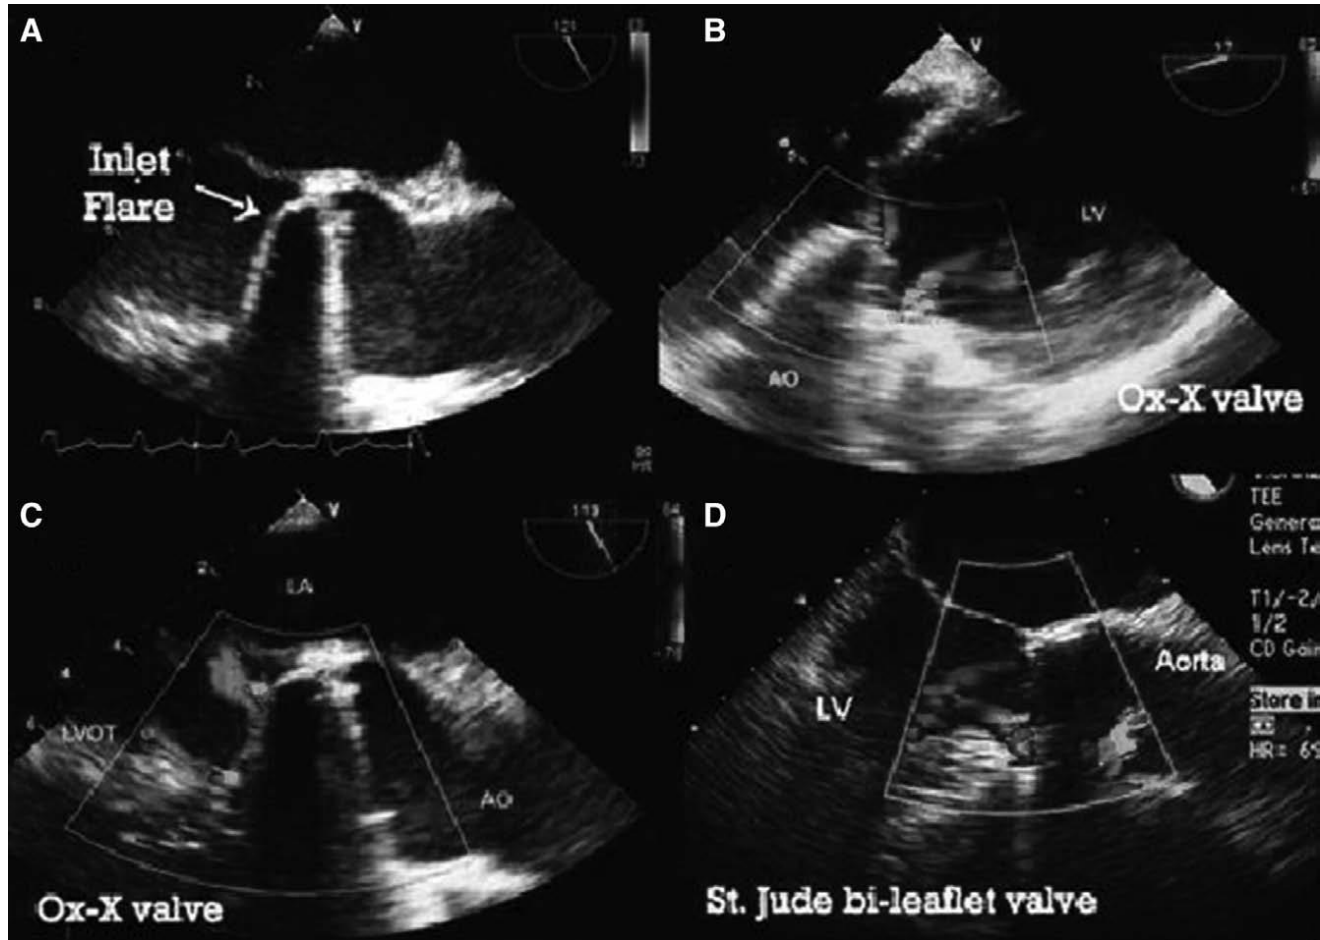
Echocardiographic features of the On-X valve (regurgitant jets positioning). A, TEE image of the On-X valve in the midesophageal long axis (ME LAX). B, Color flow Doppler image of On-X obtained in the deep transgastric view valve showing nonconverging washing jets. C, TEE image of On-X valve washing jets in ME LAX. D, TEE image of the St. Jude bileaflet valve in ME LAX showing typical converging washing jets. TEE indicates transesophageal echocardiogram.
